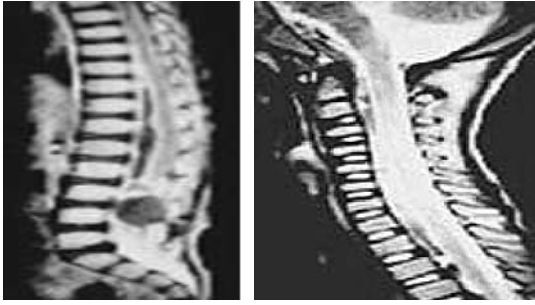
Sagittal a) enhanced T1 weighted thoracolumbar and b) T2 weighted cervical MRI sections demonstrating the intramedullary dermoid tumor (arrow) and subdural abscess all along the spinal cord.
